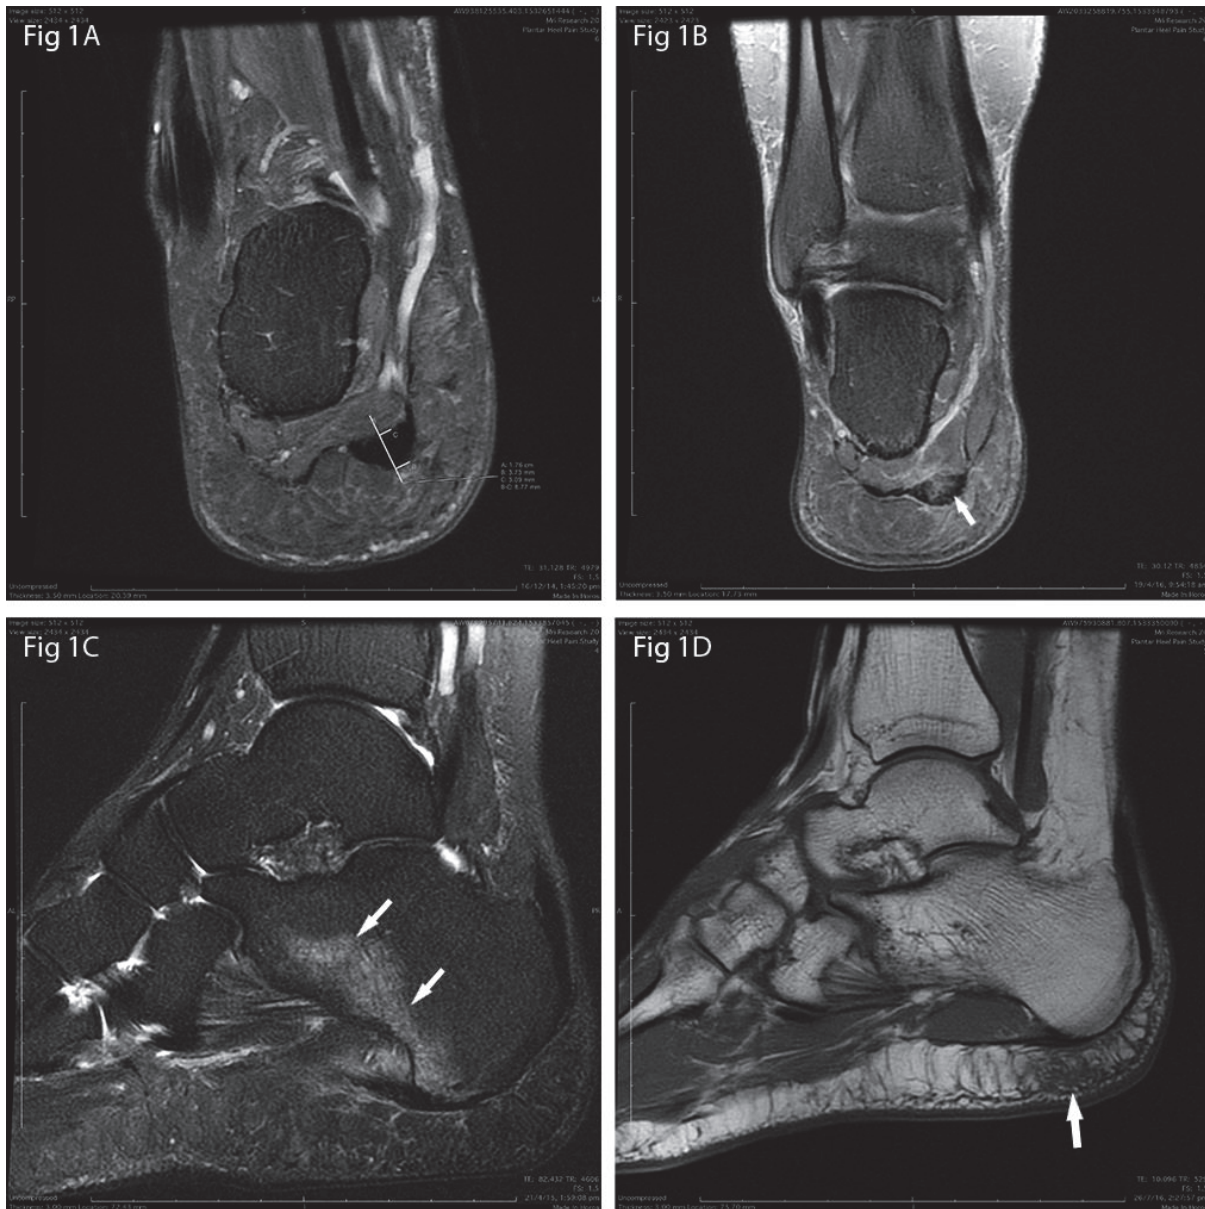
A Plantar fascia thickness, coronal PD sequence, B Intra-substance plantar fascia signal (Grade 2), coronal PD sequence, C Calcaneal BML signal, sagittal T2-weighted sequence, D Plantar fat pad signal, sagittal T1-weighted sequence (Grade 2)
